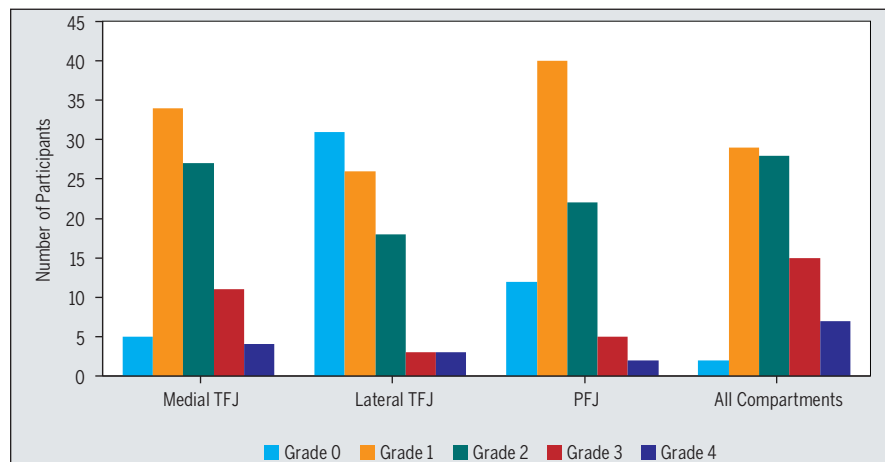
Knee ROA prevalence by compartment and severity ($n = 81$). "All compartments" presents the highest grade of ROA from any compartment for each participant. A Kellgren-Lawrence grade of 0 represents no radiographic changes, grade 1 represents minimal changes, grade 2 represents definite but minimal changes, grade 3 represents moderate changes, and grade 4 represents severe radiographic changes.¹⁴ If both knees were reconstructed, the highest severity of ROA in either knee was reported for each compartment. Abbreviations: PFJ, patellofemoral joint; ROA, radiographic osteoarthritis; TFJ, tibiofemoral joint.
